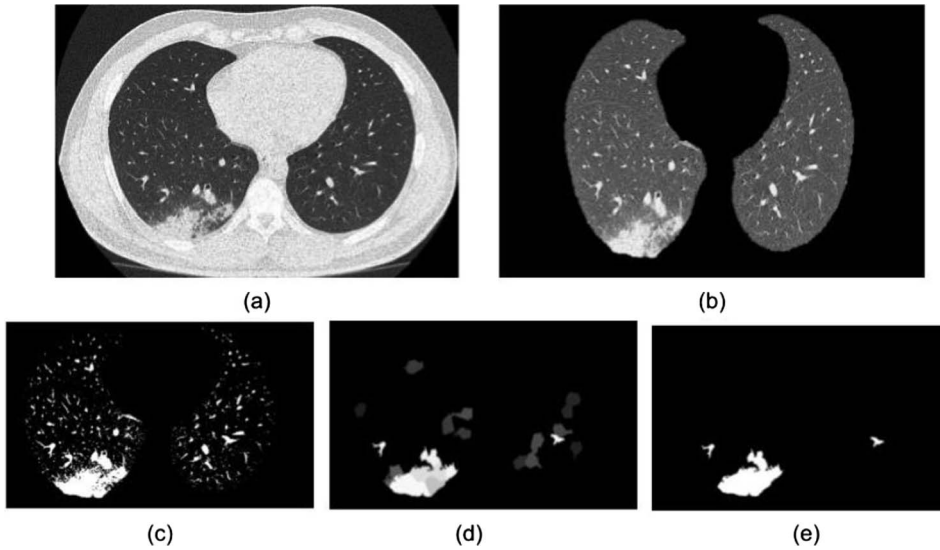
Images representing sequential stages of the threshold-based segmentation method to quantify COVID-19 lung infection: (a) original CT slice, (b) 2D segmented lungs, (c) implemented binary thresholding, (d) implemented region adjacency graph thresholding, and (e) additional thresholding, which may be used to compute the hyperintensity density of segmented regions to compare with the total mask pixel density.
